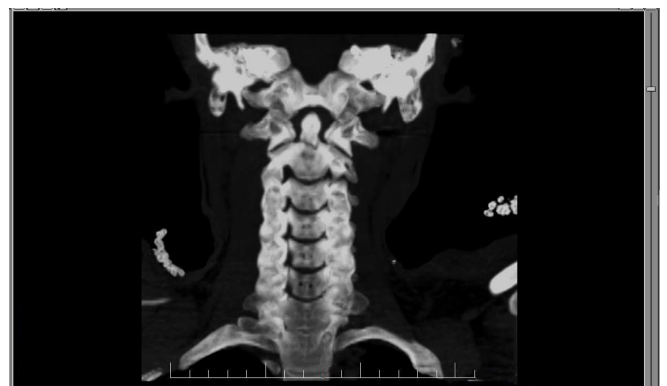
A three-dimensional coronal reformatted computed tomography scan of the cervical spine. The image confirms complete irregularity. A fracture at the base of the odontoid process (C2) is shown.
